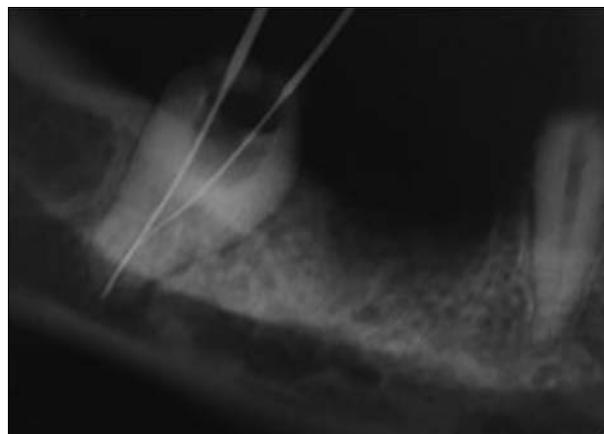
Periapical radiography with hand files showing close contact between neurovascular bundle of tooth 47 and mandibular nerve
